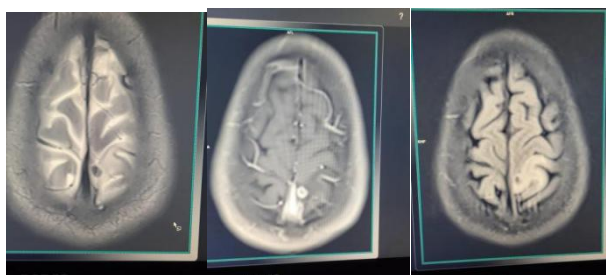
shows Round small T1, T2 hypointense, FLAIR hyper intense lesion, not showing diffusion restriction, on post contrast ring enhancement noted. S/o Neurocysticercosis.
